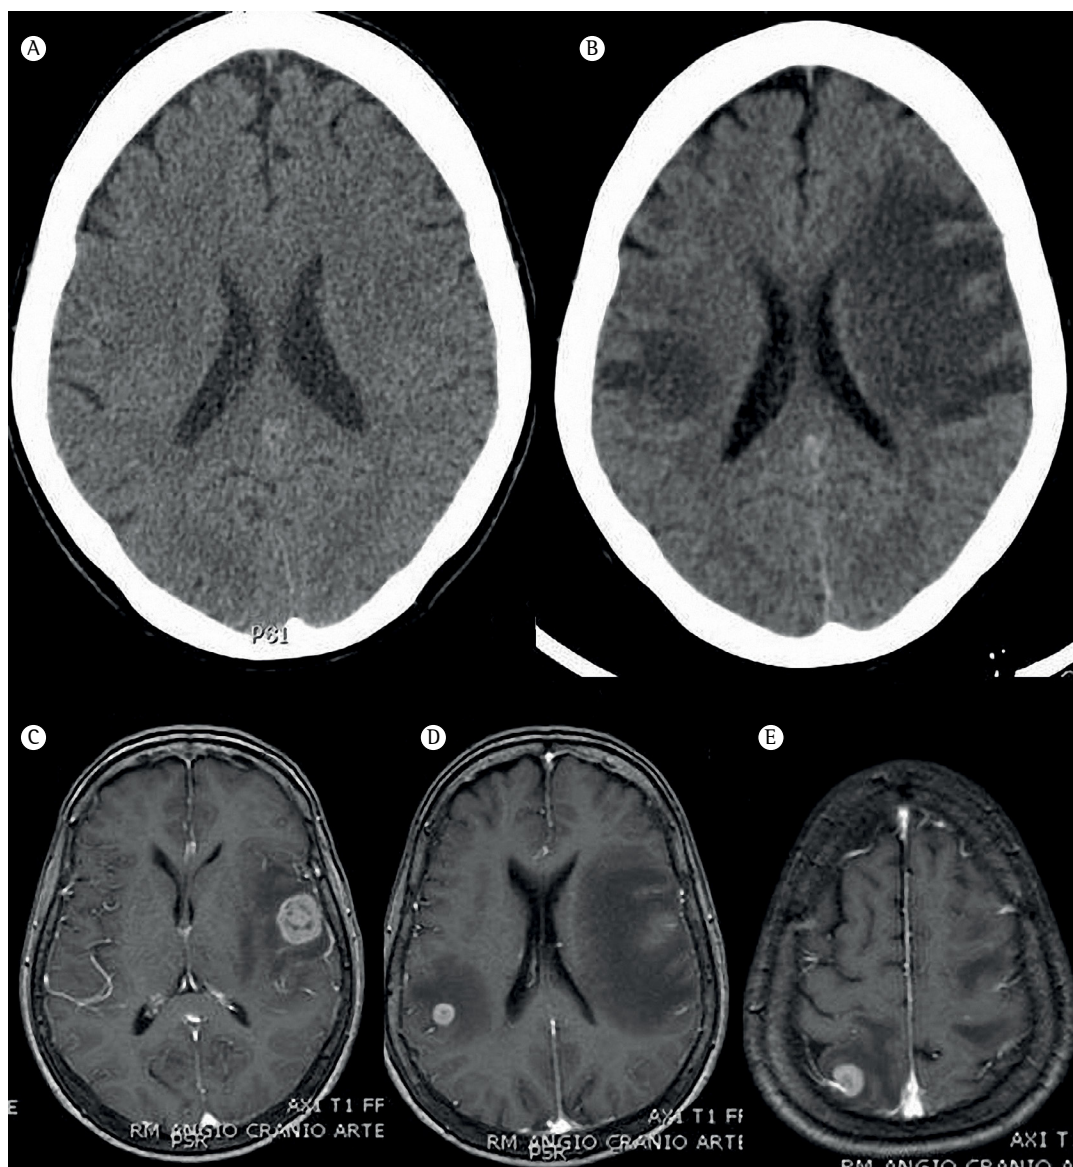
Neuroimaging scans. In A, a CT scan of the skull taken when the pulmonary mass was discovered four months prior to the appearance of neurological symptoms, which is apparently normal. In B, a CT scan of the skull taken four months after readmission, when the patient presented with neurological symptoms. In C-E, magnetic resonance imaging scans revealing details of the metastatic spread and intense vasogenic edema.
